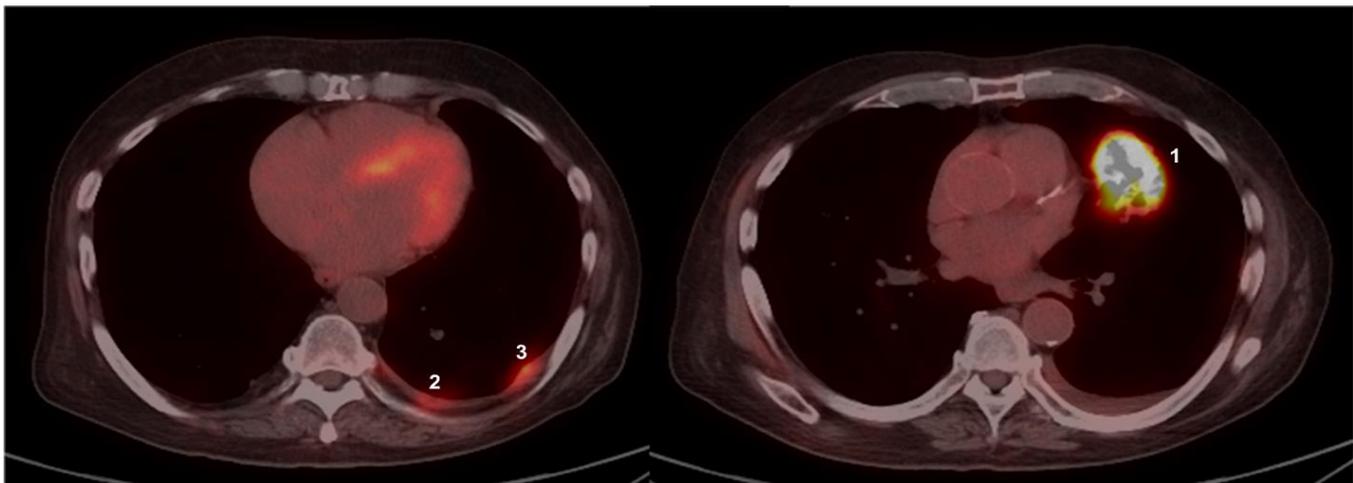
Positron emission tomography-computed tomography. There were 3 areas with hypermetabolic activity: (1) Lung mass in the left upper lobe; (2) lung nodule; (3) lung nodule.
